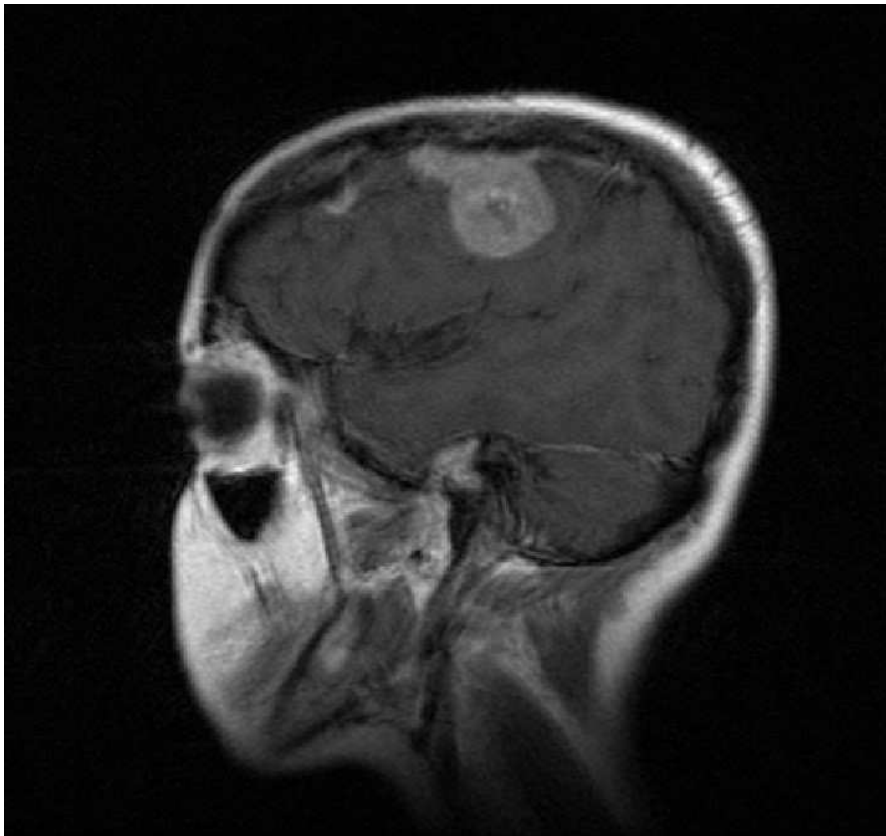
Sagittal, contrast-enhanced T1-weighted Magnetic Resonance Image of a NF2 individual presenting a meningioma. In the initial phases, symptoms may be absent
